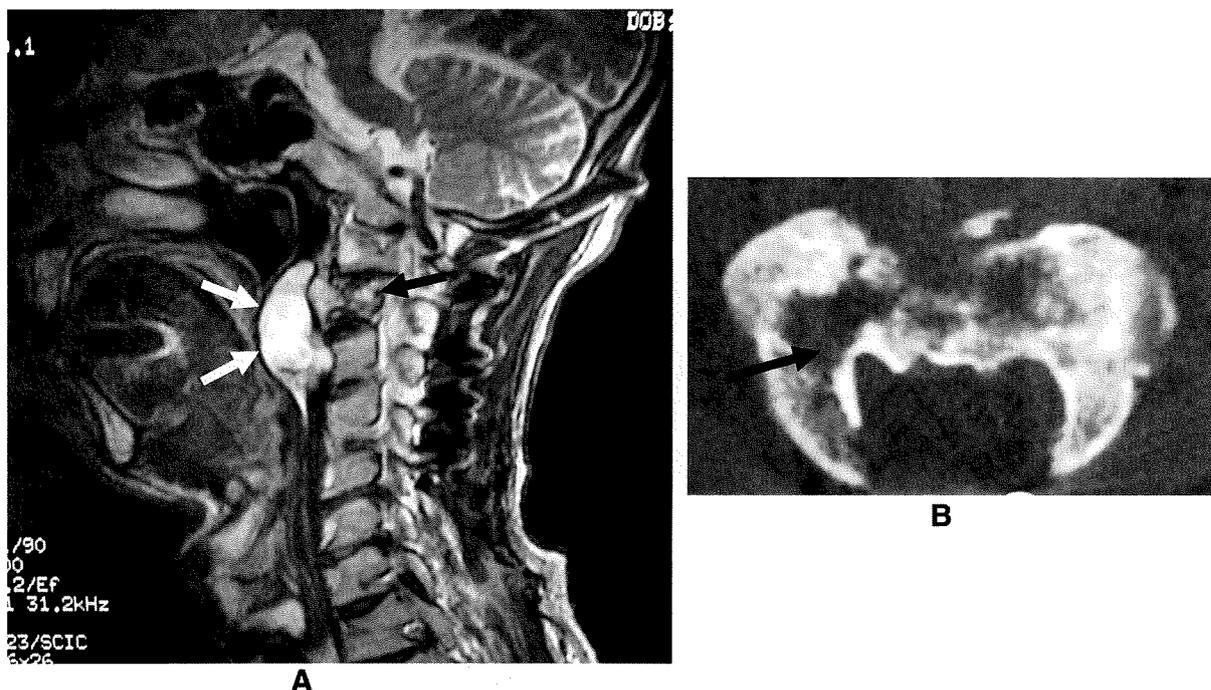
Case 2. Images taken when the patient was introduced to us. A, Sagittal T2-weighted MR image of the cervical spine. A retropharyngeal tumor (white arrows) and pathologic fracture of C2 (black arrow) were demonstrated. B, CT image of C2. In this section, the osteolytic lesion expanded posterior to the right vertebral artery (arrow).
